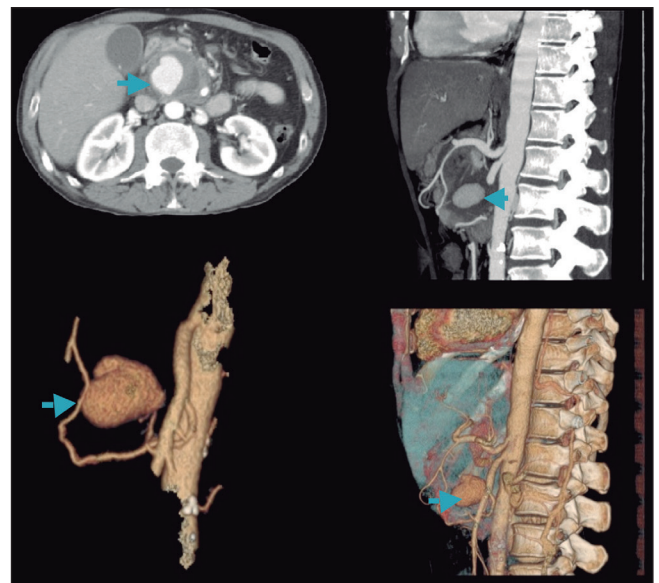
Abdominal-pelvic CT in arterial and portal phase. Reconstruction in axial, coronal and sagittal axis and 3D. Pseudoaneurysm (arrows) dependent on a branch of the pancreaticoduodenal arcade, probably secondary to previous pancreatitis, leading to an obstruction of the intra- and extrahepatic bile duct and the pancreatic duct. Furthermore, the pseudoaneurysm presents mural thrombus, and other signs previous to rupture.
